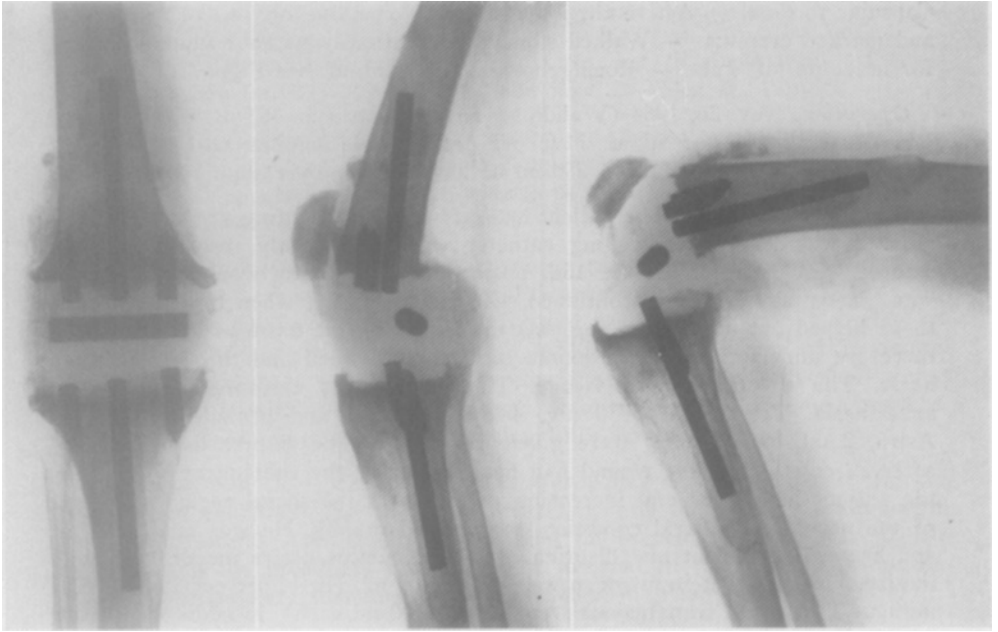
Case 1: roentgenograms 3 years 1 month after arthroplasty of right knee.
